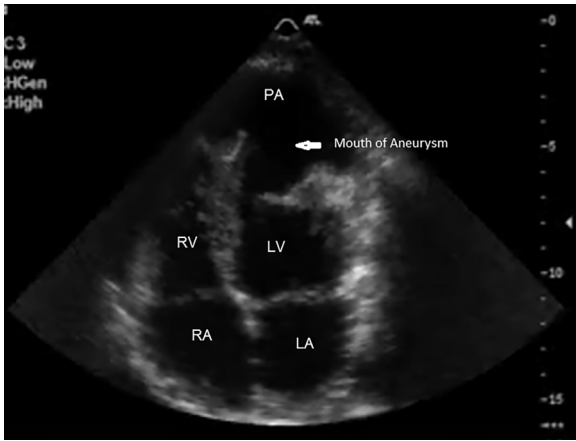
Transthoracic echocardiogram of the apical four chamber view showing large pseudoaneurysm of the apex of the left ventricle. Myocardium showing abrupt cut off with myocardial discontinuity and the aneurysm is lined by a thin layer of tissue devoid of myocardium.
